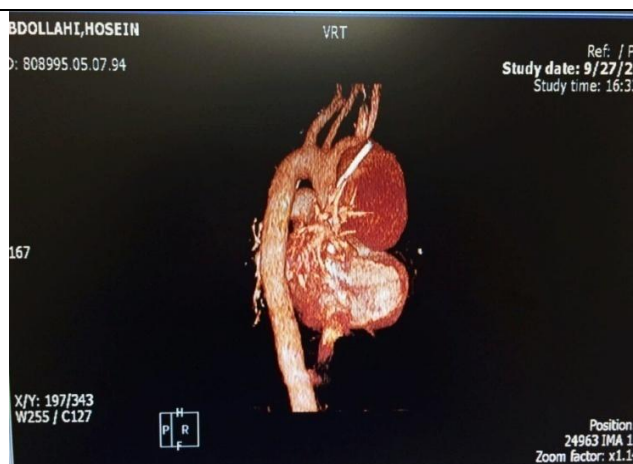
3D imaging by mediastinal computed tomography scan.
